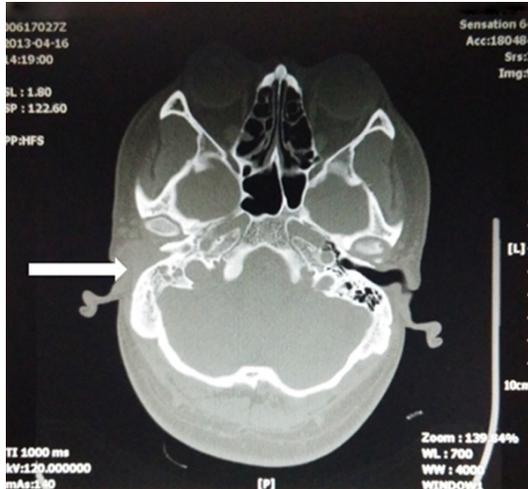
Computed tomography (CT) revealed the complete obstruction of right external auditory canal and absence of the normal mastoid air cells.
